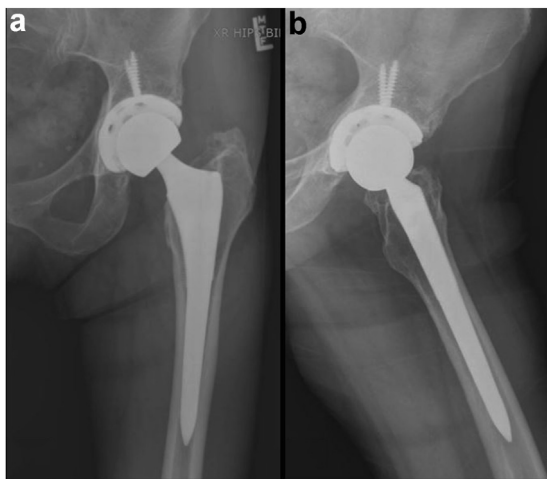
(a) Anteroposterior and (b) lateral radiographs postoperative revision surgery of the same patient.
